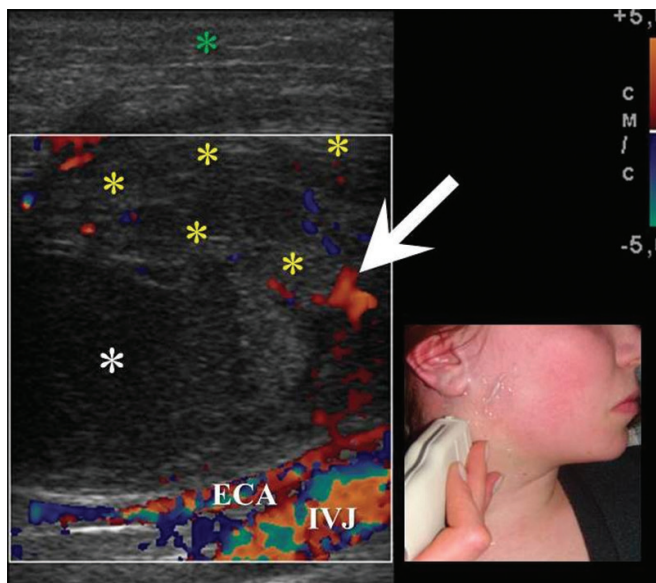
An infected BCC in a 18-years-old female. Longitudinal color Doppler ultrasound shows cystic oval shape lesion with hypoechoic content (white asterisk). Note inflammatory hyperemia of sternocleidomastoid muscle (yellow asterisks) in a form of its increased vascularity (arrow). Edema, decreased echogenicity of the surrounded tissues is marked by green asterisk. Lesion is avascular, adjacent to the neurovascular bundle of the neck. External carotid artery and internal jugular vein are marked by ECA and IJV.
